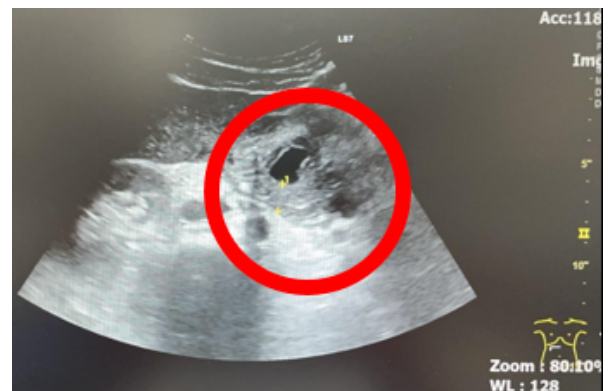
Abdominal sonography showing wall thickening over the proximal duodenum (red circle).
